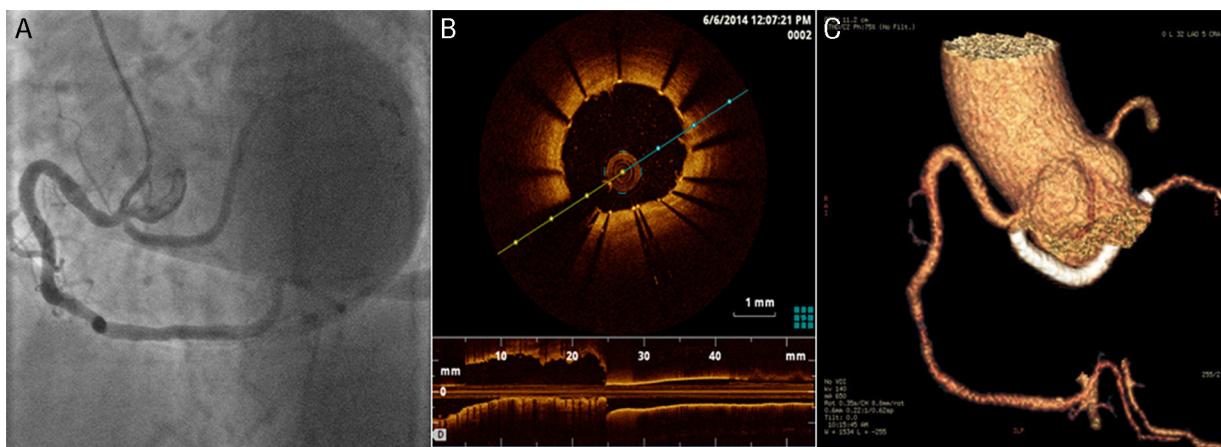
(A) Final angiographic result. (B) Optical coherence tomography image showing good stent apposition. (C) Coronary computed tomography angiogram after angioplasty.
